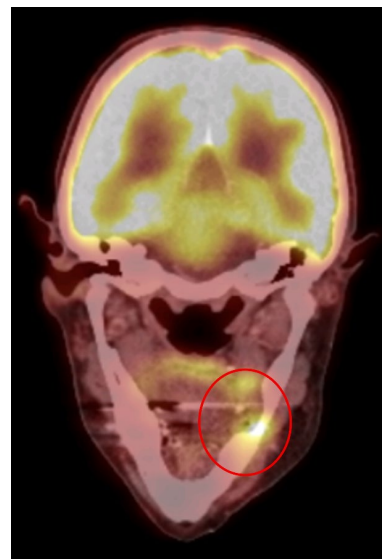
PET/CT 6 months after treatment.
